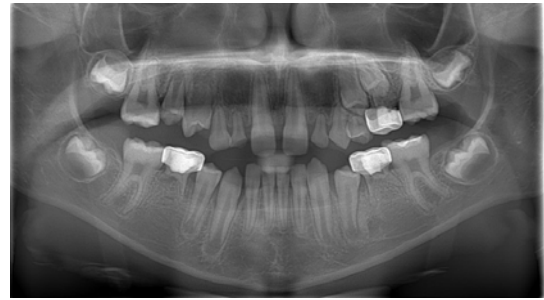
Orthopantomogram, AA.
